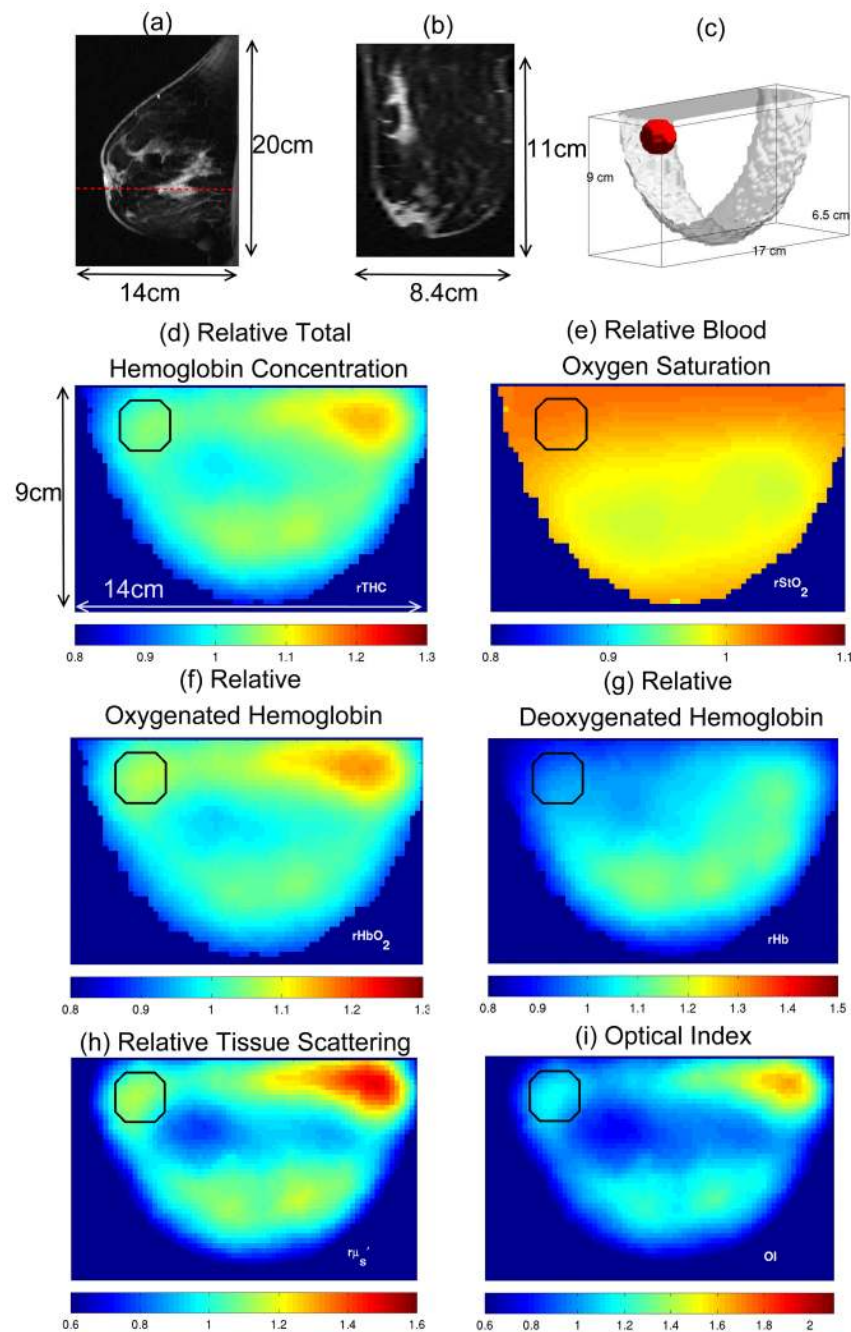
MR image and DOT image of a 51-yr-old woman with a 5 mm fibroadenoma in her left breast. The DCE-MR image shows an asymmetric density exhibiting some enhancement in lower outer quadrant. Since the optical contrast was not apparent, a spherical region was assigned as a benign lesion in DOT images (black solid line) based on the extent of gadolinium enhancement in DCE-MR image. Tumor-to-normal contrast in all parameters and *OI* are similar to that of surrounding tissue.
